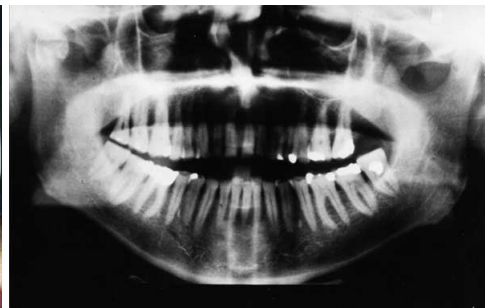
X-ray OP in case of condylar neck fracture with mild dislocation
